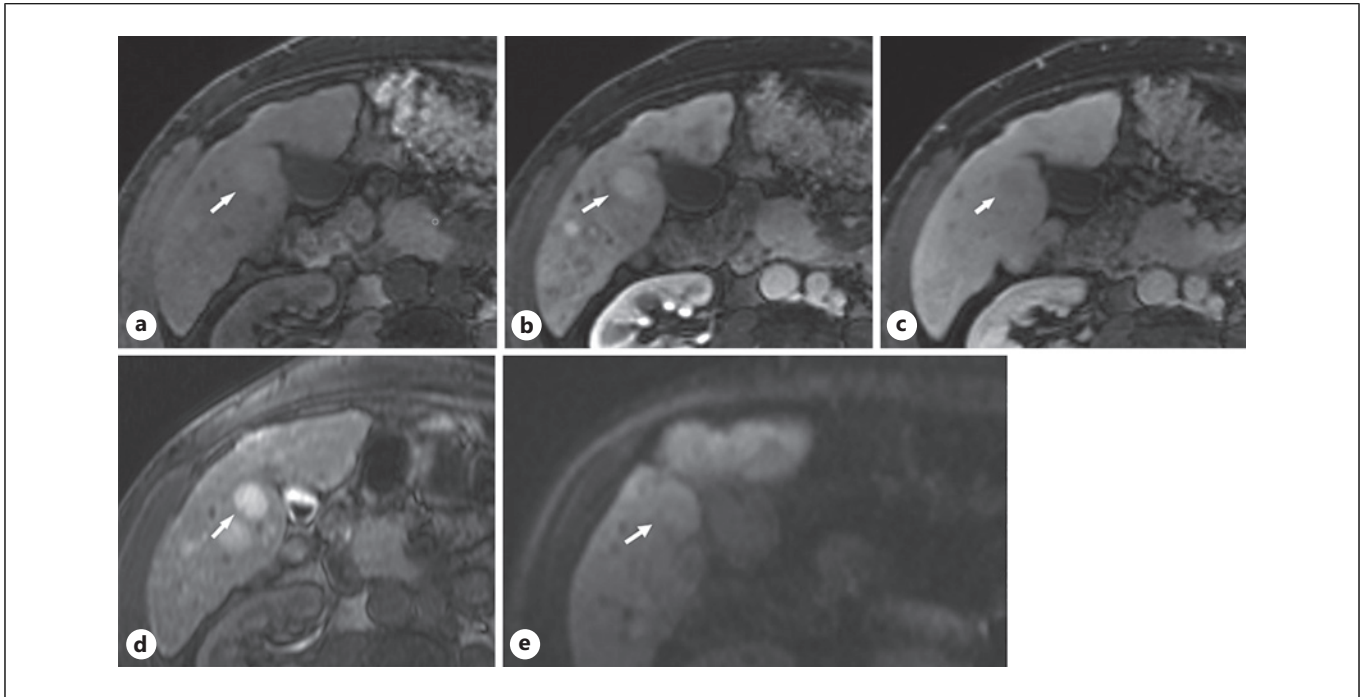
Suspicious nodule in a patient with BCS. 18 mm nodule in segment 5 (arrows). EC-MRI baseline (a), arterial (b), and portal phase (c). d HB-MRI HBP. e DWI with high b value. The nodule shows non-rim APHE (b) and washout in the portal phase (c) and it is homogeneously hyperintense in the HBP (d) and there is no diffusion restriction (e).
